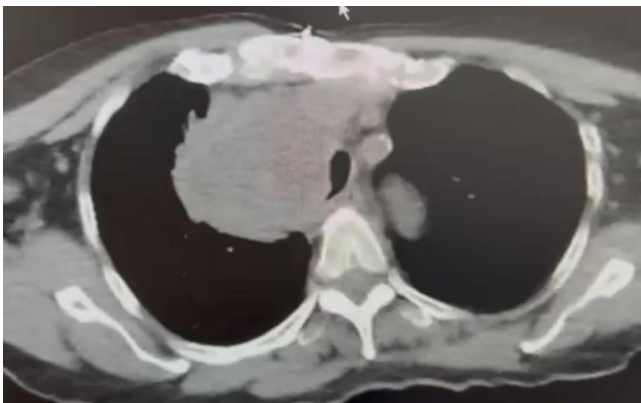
Mediastinal lesion on thorax CT
